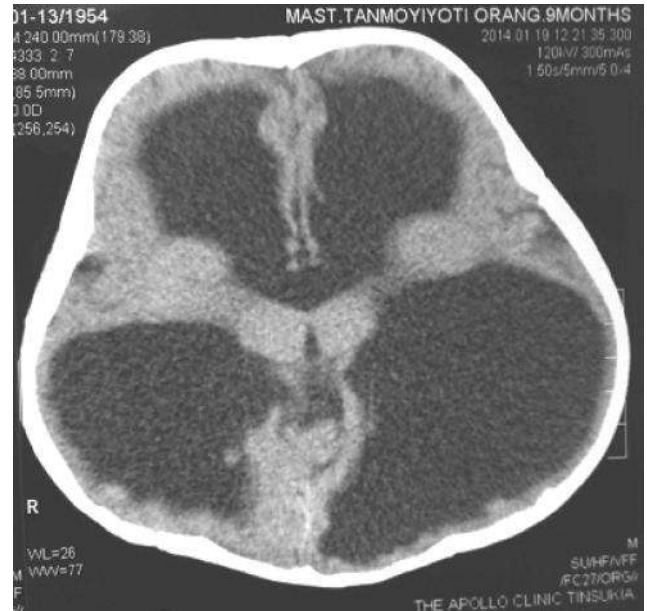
Post-operative CT scan of the brain after 1 month showing reduction in the ventricular size and increase in the cerebral mantle
